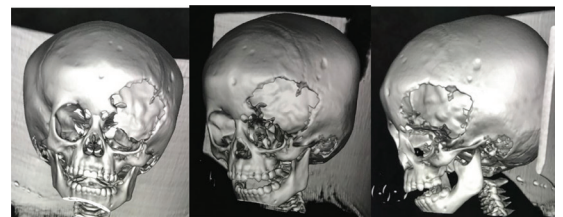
Facial disfigurement with CT scan 3D reconstruction (before reconstruction)
